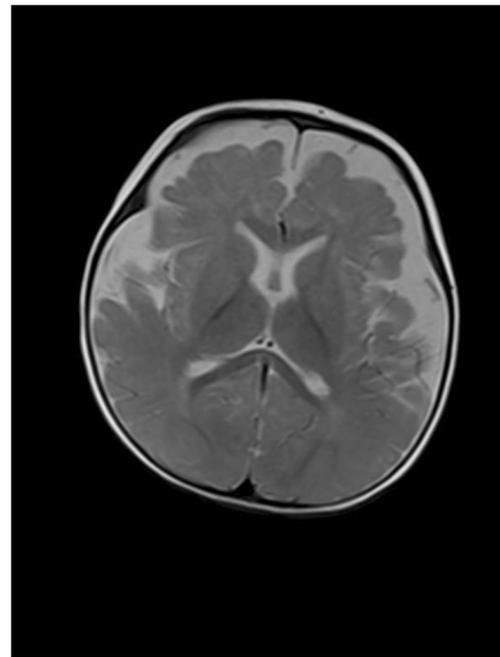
A 9-month-old boy with vit. B12 deficiency. In the axial T2-weighted image, brain atrophy can be seen
